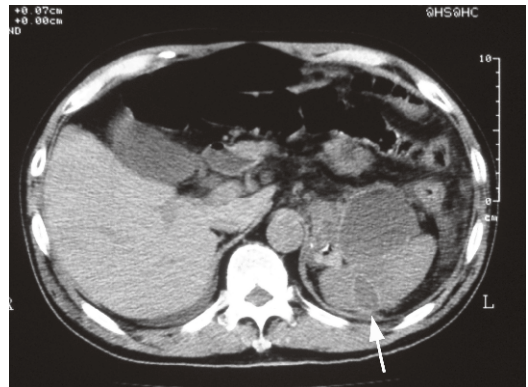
On admission, emergency CT revealed an enlarged pseudocyst in the tail of the pancreas which directly extended into the splenic parenchyma (arrow).
